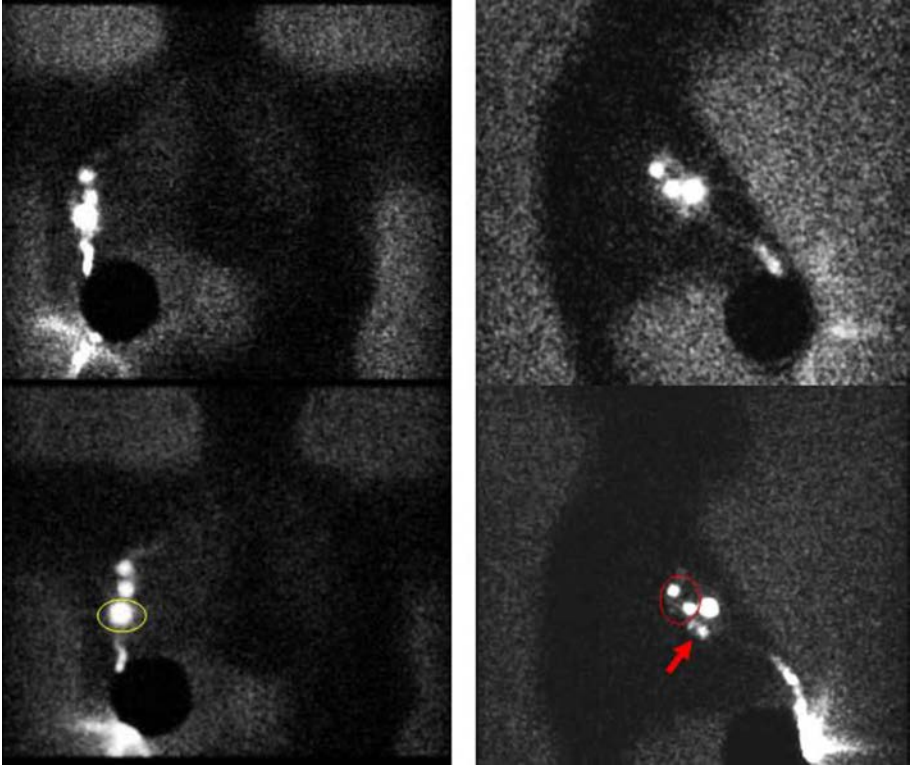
Lymphoscintigraphy of a patient with cancer in the right breast. After injecting 111 MBq of  $^{99m}\text{Tc}$  nanocolloid, one definitive SLN is depicted, with another focus of faint uptake nearby (A). The SPECT/CT image performed 2 h after radiocolloid injection provides superior anatomic localization of the SLNs, with impacts on surgical planning (B, C). The SPECT/CT image located on one of these nodes is in the anatomical Berg level 1, and the other is in Berg level 2.
